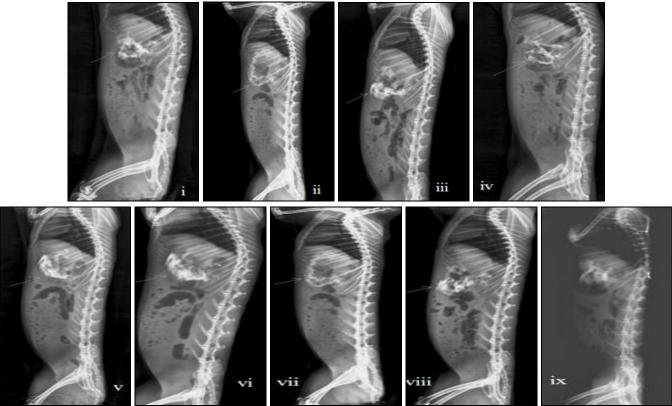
IN-VIVO* X-RAY IMAGING STUDIES OF THE PIOGLITAZONE OPTIMIZED FORMULATION. i) x-ray image of Immediately after administration ii) x-ray image After 0.5 hr after gel administration iii) X-ray image after 1 h of gel administration and iv, v, vi, vii-viii & ix are X-ray images after 2, 4, 6, 8, 10 and 12 h of gel administration.
